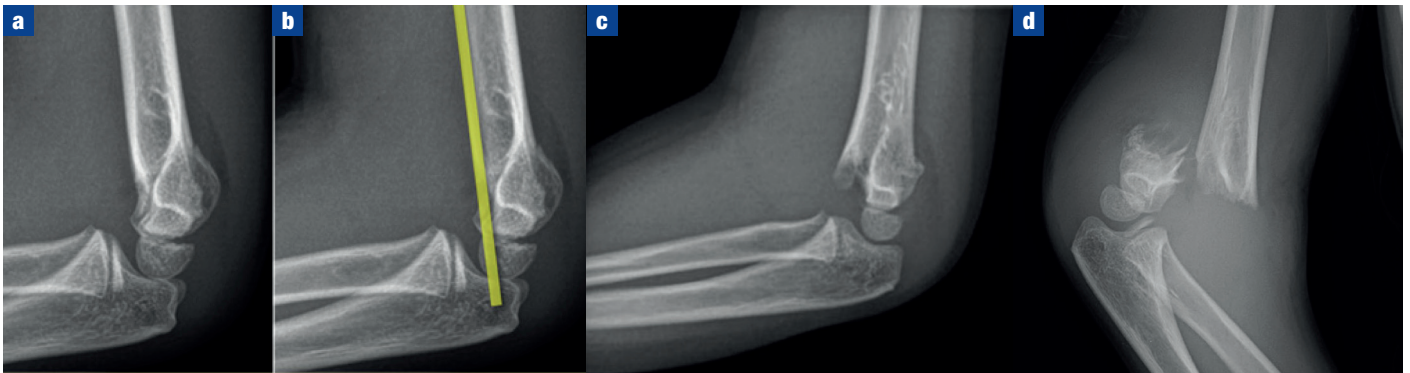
Lateral radiographs of the elbow demonstrating (a) a Gartland type I supracondylar fracture with (b) the disruption of the anterior humeral line (yellow), (c) a Gartland type II B supracondylar fracture and (d) a Gartland type III supracondylar fracture with complete disruption of the anterior and posterior cortices.
